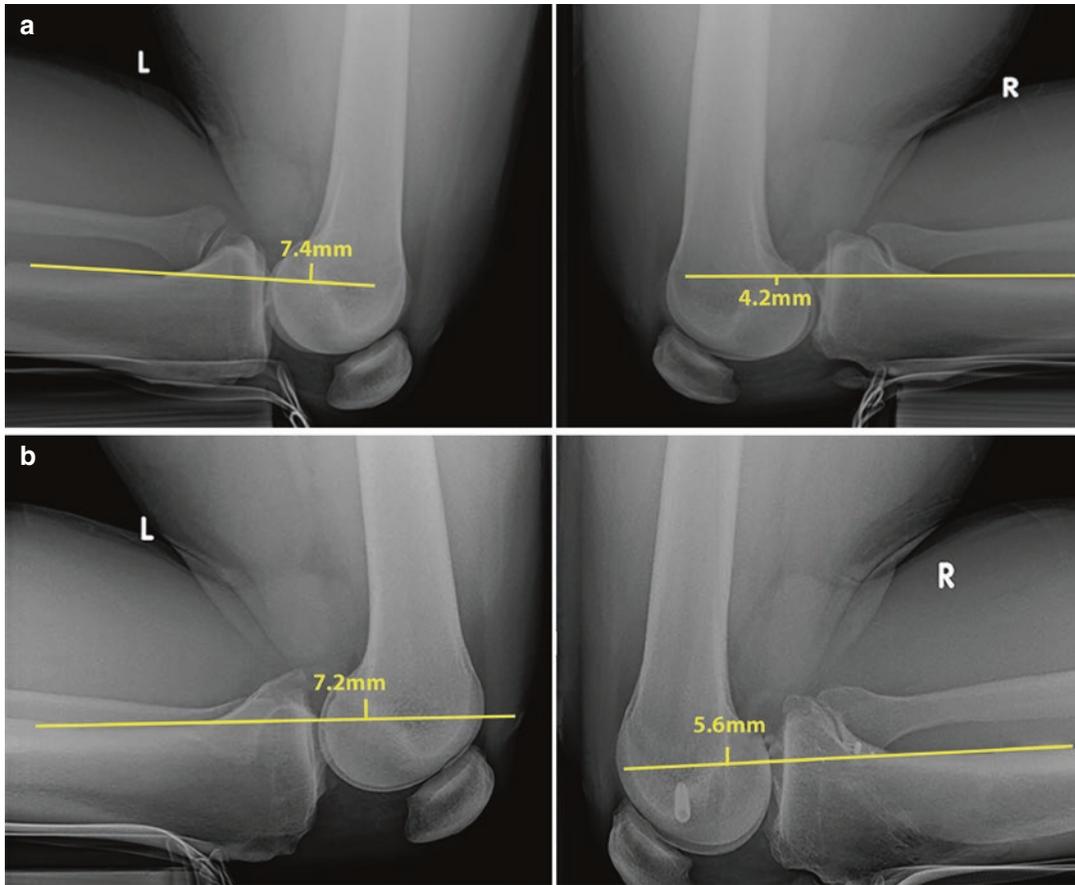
Pre- and postoperative stress radiograph (kneeling) series following double-bundle PCL reconstruction, ACL reconstruction. (a) Preoperative side-to-side kneeling stress radiographs. (b) 12-month
